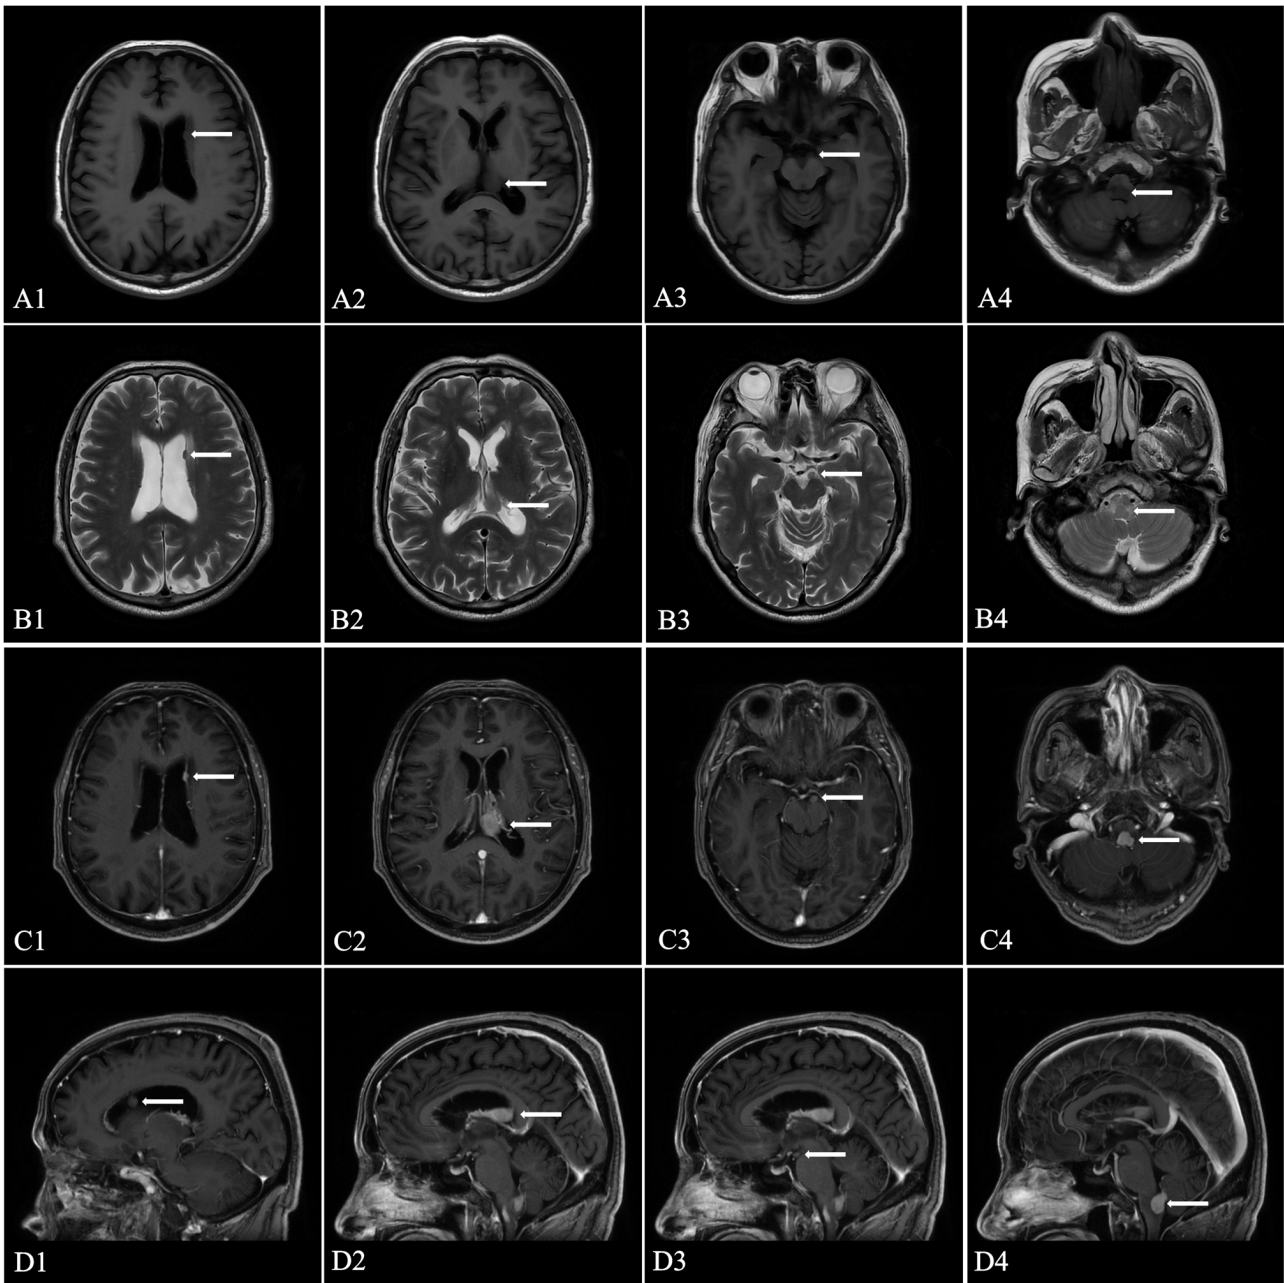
Pre-operative MRI. (A1-4) Lesions (arrow) in the lateral ventricle, interpeduncular cistern and 4th ventricle and medulla showed a slightly longer signal on axial T1-weighted MRI. (B1-4) The lesions (arrow) in the lateral ventricle, interpeduncular cistern and 4th ventricle and medulla showed a slightly longer signal on axial T2-weighted MRI. (C1-4) The lesions (arrow) in the lateral ventricle, interpeduncular cistern and fourth ventricle and medulla showed a notable enhancement on axial gadolinium-enhanced MRI. (D1-4) The lesions (arrow) in the lateral ventricle, interpeduncular cistern, 4th ventricle and medulla showed a notable enhancement on sagittal gadolinium-enhanced MRI. MRI, magnetic resonance imaging.
